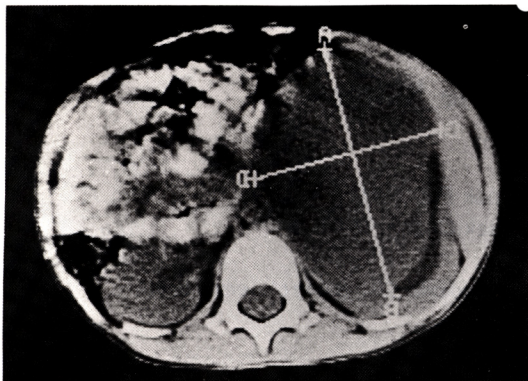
Abdominal CT reveals an enlarged right kidney with homogeneous density and peripheral fluid density with laterally displaced renal parenchyme.
